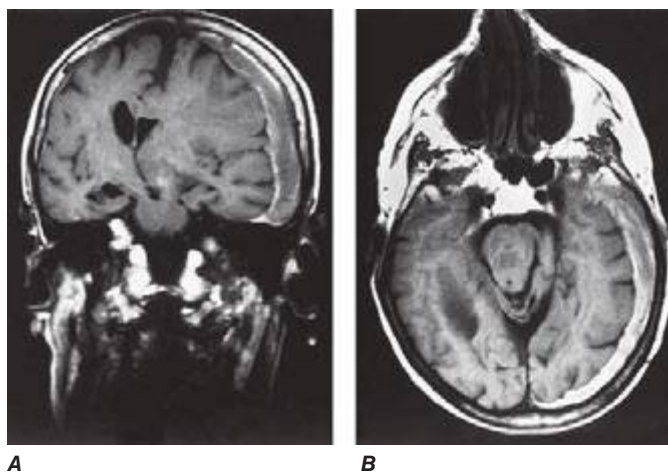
Coronal (A) and axial (B) magnetic resonance images from a stuporous patient with a left third nerve palsy as a result of a large left-sided subdural hematoma (seen as a gray-white rim). The upper midbrain and lower thalamic regions are compressed and displaced horizontally away from the mass, and there is transtentorial herniation of the medial temporal lobe structures, including the uncus anteriorly. The lateral ventricle opposite to the hematoma has become enlarged as a result of compression of the third ventricle.
